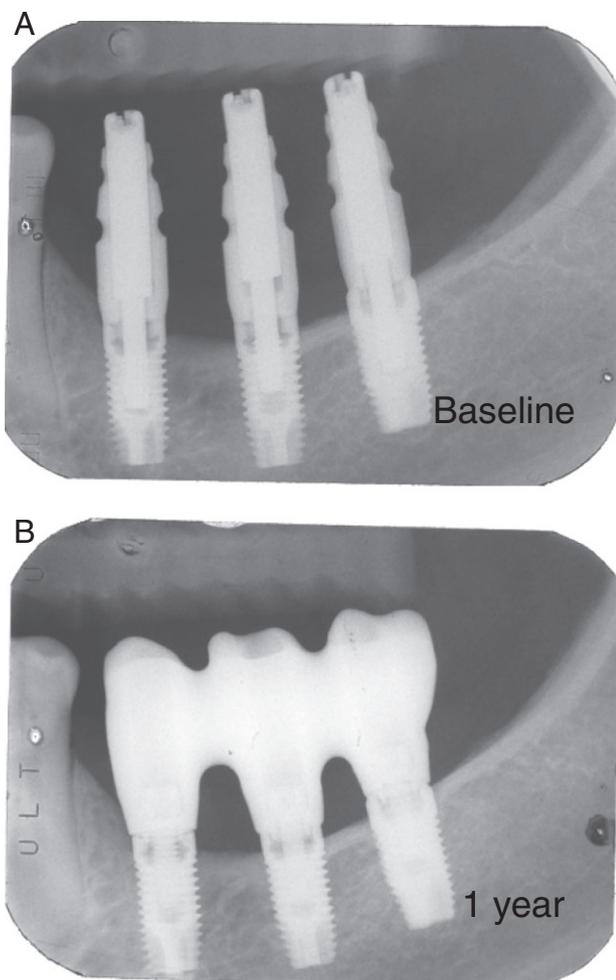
A, Clinical radiographs of three NEOSS implants placed in the posterior mandible after completed healing. B, Clinical follow-up radiograph after 1 year in clinical function of three-unit bridge construction. Note stable bone levels and corticalization of the marginal bone adjacent to the implants.
